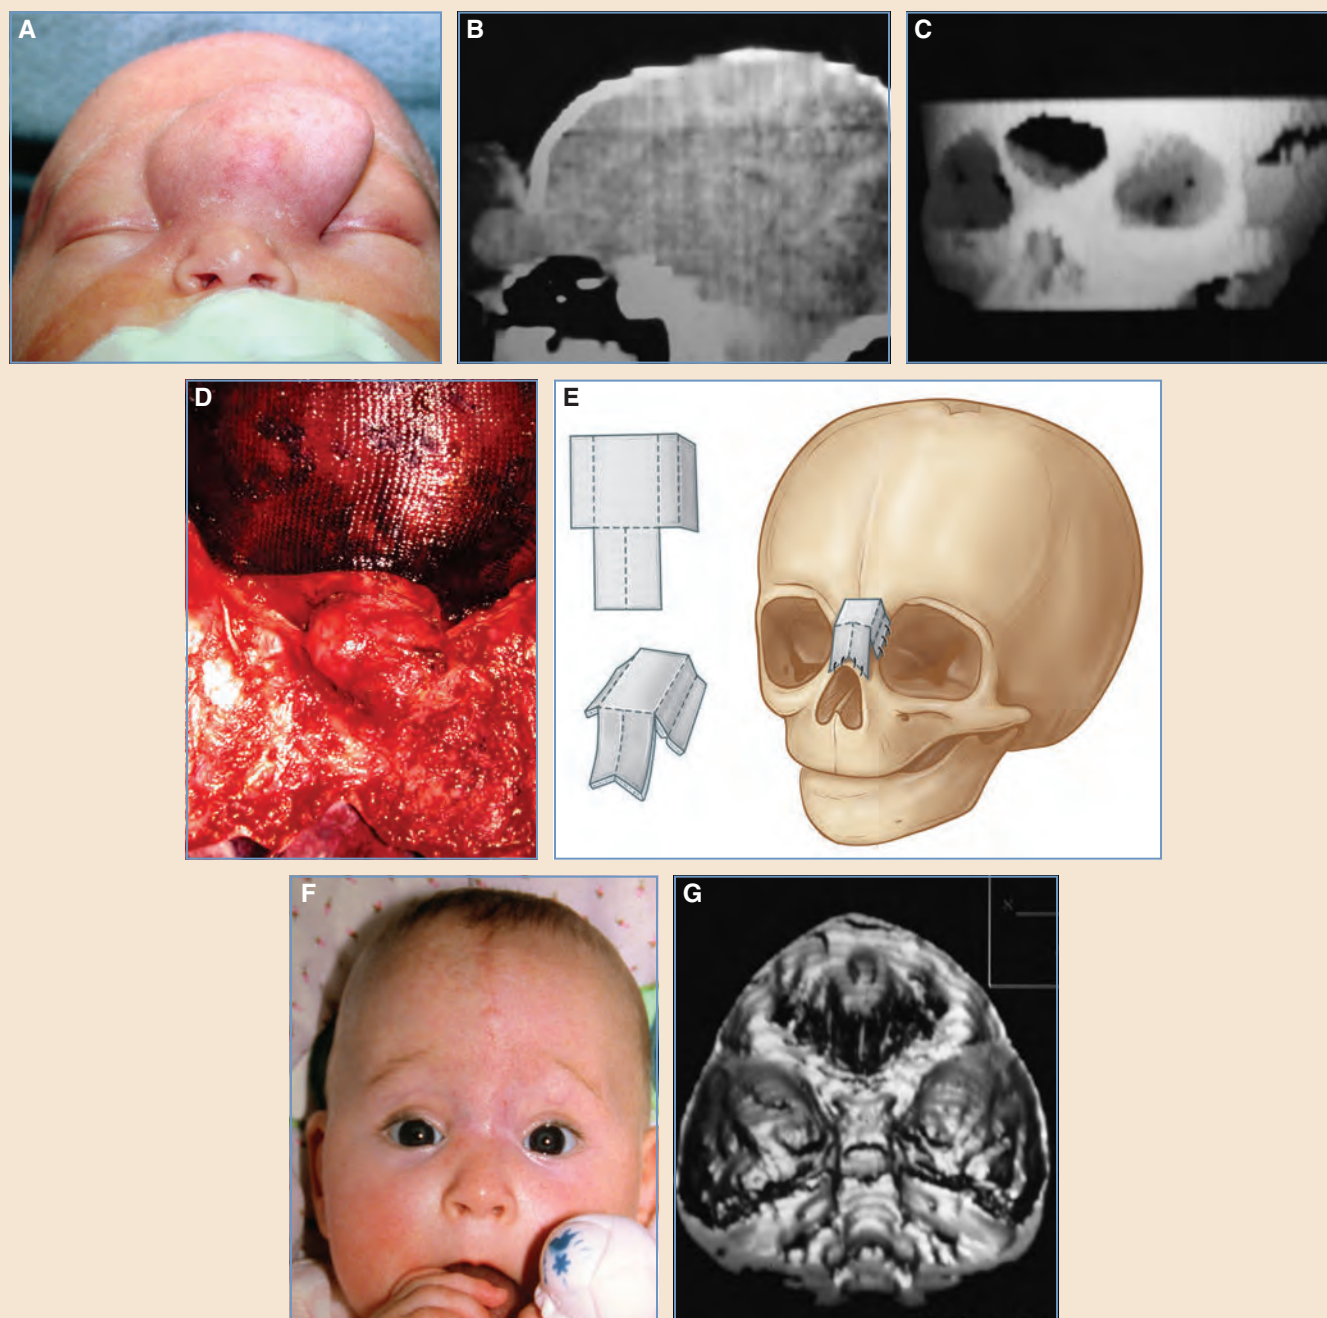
A, Frontonasal encephalocele in a newborn infant. B, Midsagittal CT view shows a defect in the area of the previous fonticulus nasofrontalis. The continuity of the dura is also shown. C, The defect is shown on a three-dimensional CT scan. D, Intraoperative view of the encephalocele after it was fully exposed and before resection. E, A cranial bone graft was used to reconstruct both the anterior cranial base and nasal dorsum. F, Six months after repair. G, At 4 years of age, the child showed a trigonocephalic deformity with a prominent midfrontal ridge and antimongoloid slant to the orbits. This CT scan was obtained before craniofacial reconstruction with frontoorbital repositioning and frontal cranioplasty.
